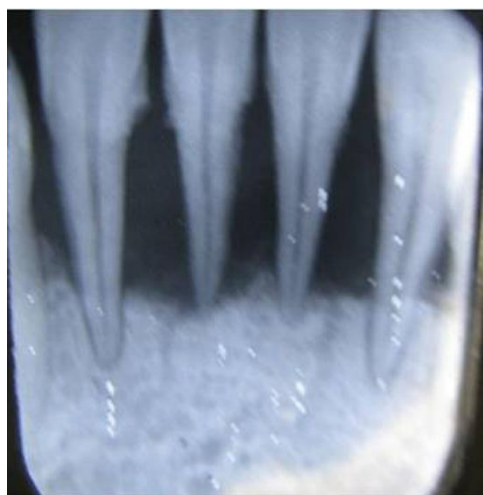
Preoperative radiograph showing horizontal bone loss extending up to the apex of the mandibular incisors.
